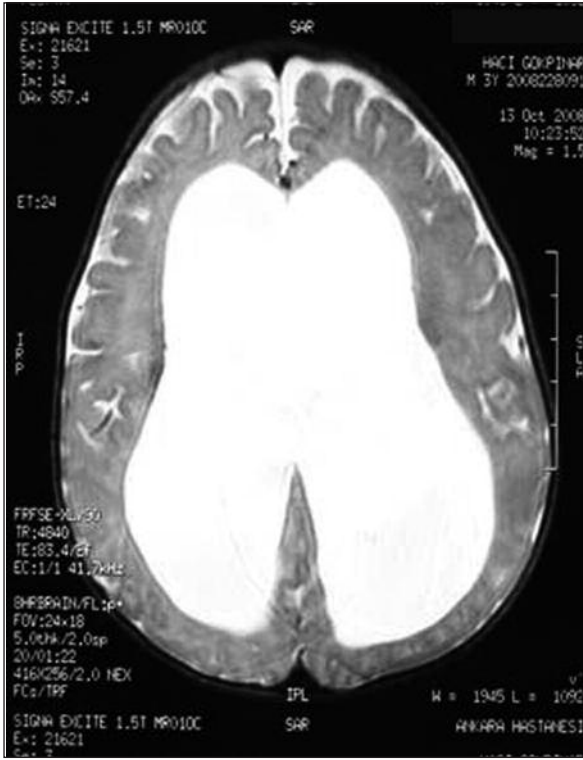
Cranial computed tomography shows hydrocephalus.
